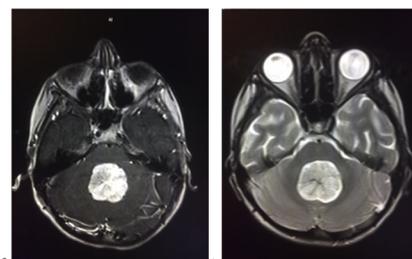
axial contrasted MRI(a) images showing typical frond like morphology with vivid homogenous enhancement(Choroid plexus papilloma), Axial T2WI (b) demonstrates a rather rounded multilobular fourth ventricular lesion, contains small cystic changes, appears isointense in T2WI.
